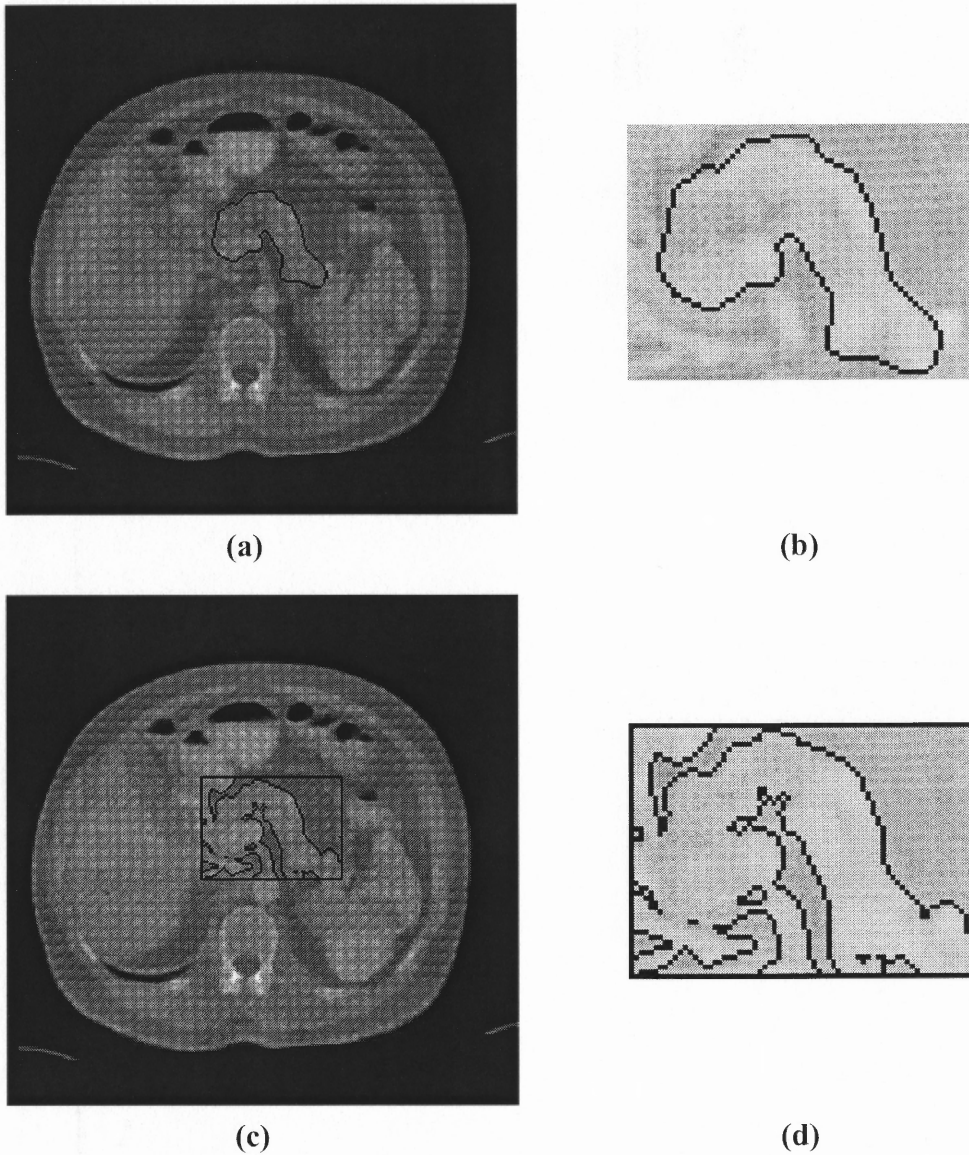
9 show the comparison between a manually traced contour and the contour as detected by the segmentation procedure. Even though the manual tracing method is not an efficient technique, it gives an approximate idea of the effectiveness of the segmentation procedure for detecting the pancreas. Figure 4.8a and 4.8c show the manually traced contour and the contour as detected by the segmentation procedure for an MR image respectively. Figure 4.8b and 4.8d show the enlarged version of the results
